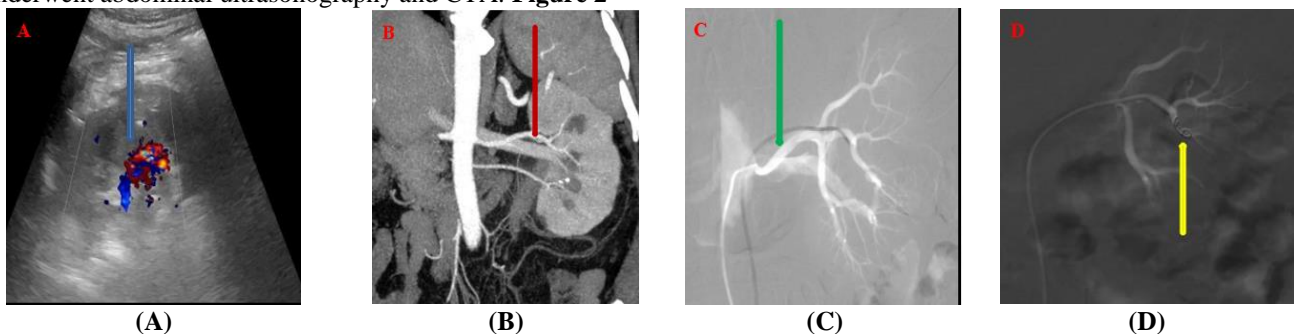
Abdominal ultrasound and color Doppler was done (A), revealed area of focal aliasing noted at left renal hilum with broad spectral flow and high PSV reaching 139cm/sec and decreasing blood flow at periphery of kidney suggesting Arteriovenous fistula (AVF) (blue arrow), then CTA of renal vessels was done, (B) revealed Double left renal arteries, Evidence of arteriovenous fistula (feeding artery middle segmental branch from main renal artery) associated with early filling of ipsilateral renal vein and IVC).(red arrow), Diagnostic selective left renal artery angiography (C) revealed Double left renal arteries, evidence of arteriovenous fistula (feeding artery middle segmental branch from main renal artery) associated with early filling of ipsilateral renal vein and IVC).(green arrow), Then super selective catheterization
